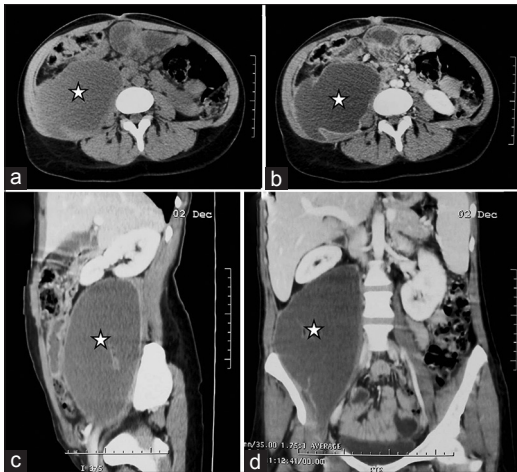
Axial abdominal and pelvic CT-scan before (a) and after (b) contrast injection. Sagittal (c) and coronal (d) abdominal reconstructions following contrast administration. There was a large right psoas muscle abscess (stars) displacing the right kidney upward. Note the presence of ring enhancement
